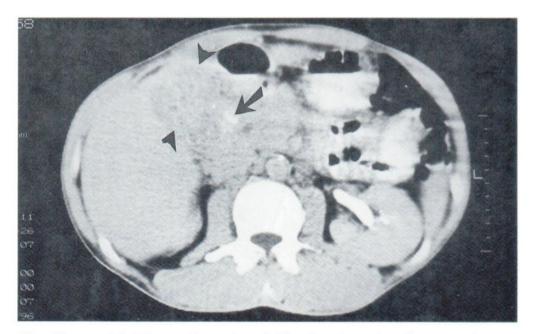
Axial CT scan showed a calcification (arrow) at the mass of gallbladder. (arrow heads)
